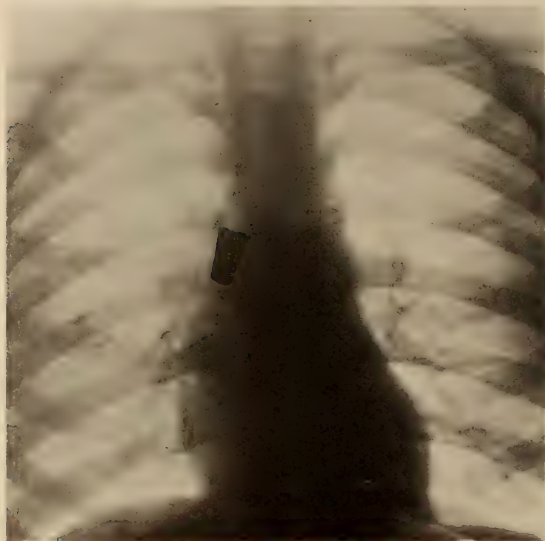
Roentgenogram showing umbrella ferrule in right bronchus.
